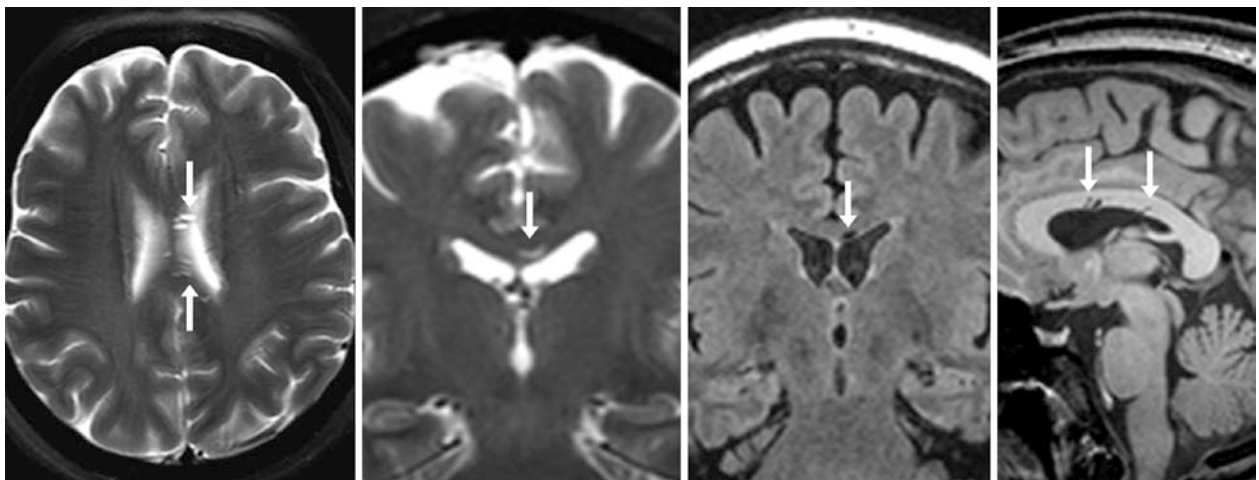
A 43 year old had an uncommon appearance of dilated PVSs within the corpus callosum body (arrows) on axial (left) and coronal (left middle) T2WIs. These appear ovoid, linear, and suppress on coronal FLAIR images (right middle), being isointense to CSF on sagittal
